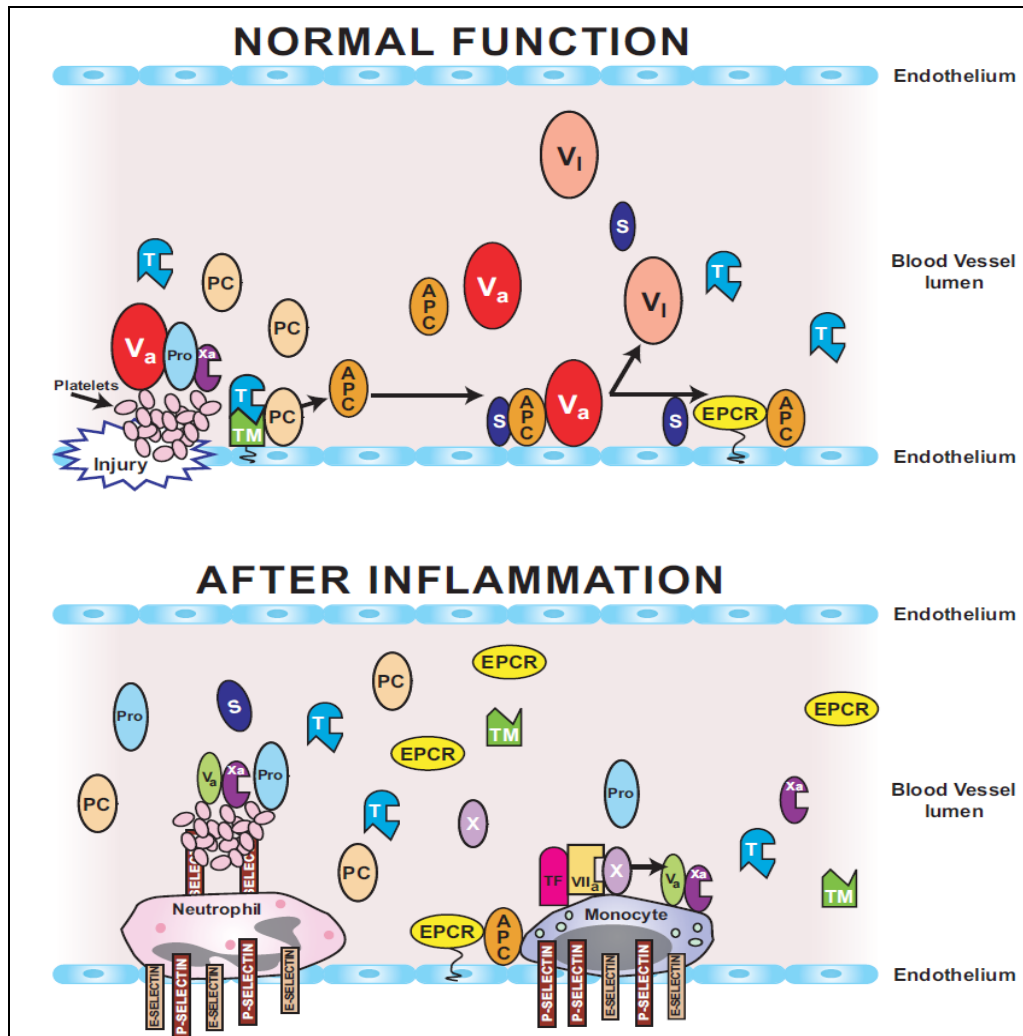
Control of coagulation in normal and inflamed vasculature. Top panel: normal function. Vascular injury, indicated on the lower portion of the blood vessel wall, initiates prothrombin (Pro) activation, which subsequently induces thrombin (T) formation. Prothrombin activation involves the formation of complexes between factor V_a and factor X_a . Thrombin then binds to thrombomodulin (TM) on the luminal side of the endothelial cell wall, and the thrombin-TM complex converts protein C to APC. APC then binds to protein S (S) on endothelial cell surfaces. The complex composed of protein S and APC then converts factor V_a into an inactive complex (V_i). Protein S and APC also interact with the endothelial cell protein C receptor (EPCR). Bottom panel: after inflammation. During inflammation, specific mediators cause the disappearance of thrombomodulin from the endothelial cell surface. The endothelial cell leukocyte adhesion molecules P-selectin and E-selectin are synthesized and expressed on the surfaces of endothelial cells or platelets. Tissue factor (TF) is expressed on monocytes where it binds to factor VII_a . The TF- VII_a complex converts factor X to factor X_a , which then complexes with factor V_a to generate thrombin from prothrombin. Very little APC is formed, and that which is formed does not function well because of low levels of protein S. Consequently, factor V_a is not activated, and the prothrombin activation complexes are stabilized. Modified from Br J Haematol, 131, Esmon CT, The interactions between inflammation and coagulation, 417–430, Copyright (2005), (Reprinted with permission from corresponding author. Daniel, G. R. (2007). Biological Perspectives Pathophysiology of Sepsis. *BAm J Pathol*, 170, 1435–1444)
